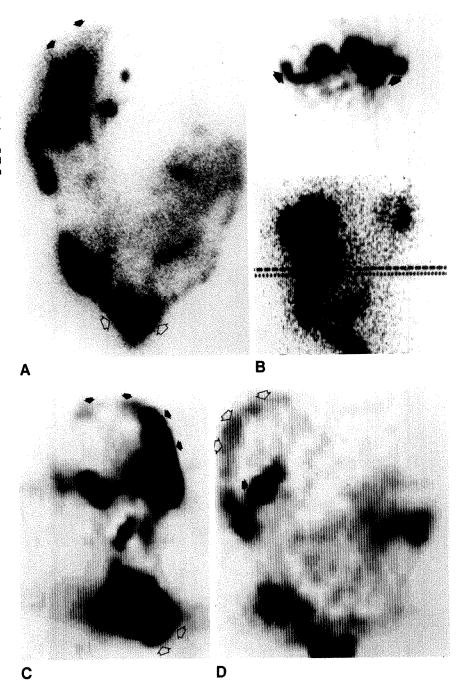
Normal SPECT of peritoneal cavity.
